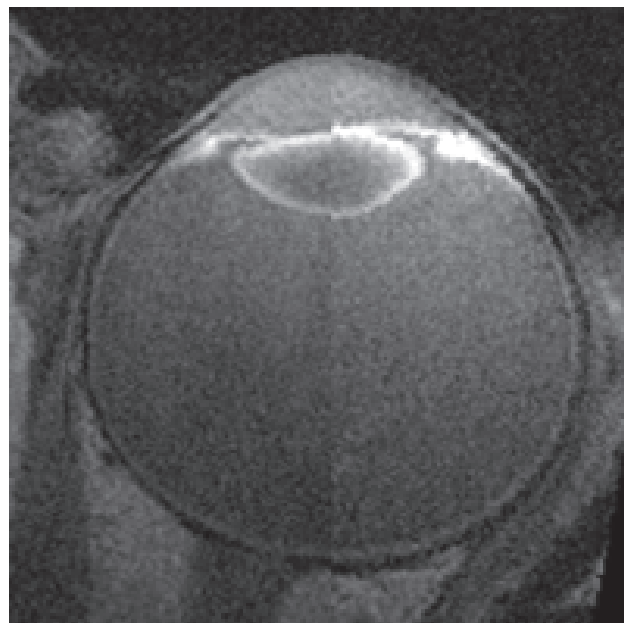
Shows the mechanism of accommodation in human (with permission, from: Strenk SA, Strenk LM, Semmlow JL, DeMarco JK. Magnetic resonance imaging study of the effects of age and accommodation on the human lens cross-sectional area. *Invest Ophthalmol Vis Sci.* 2004;45(2):539-45)
